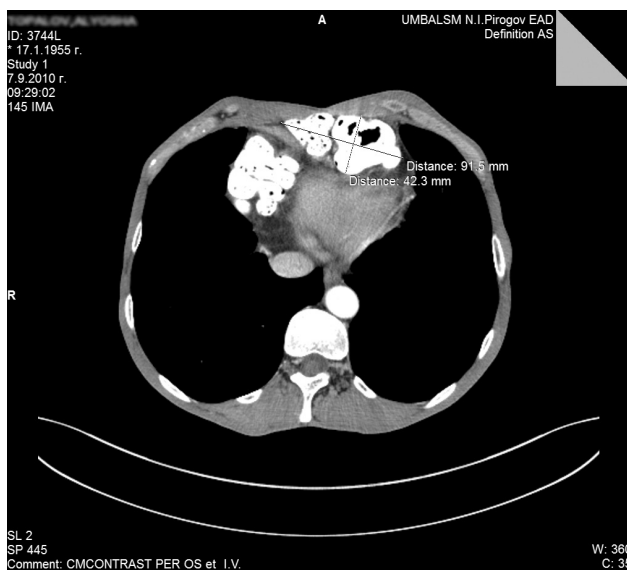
Preoperative axial computed tomography (CT) scan demonstrating diaphragmatic defect containing herniated into the thorax intestinal loops and mesenteric tissue.
